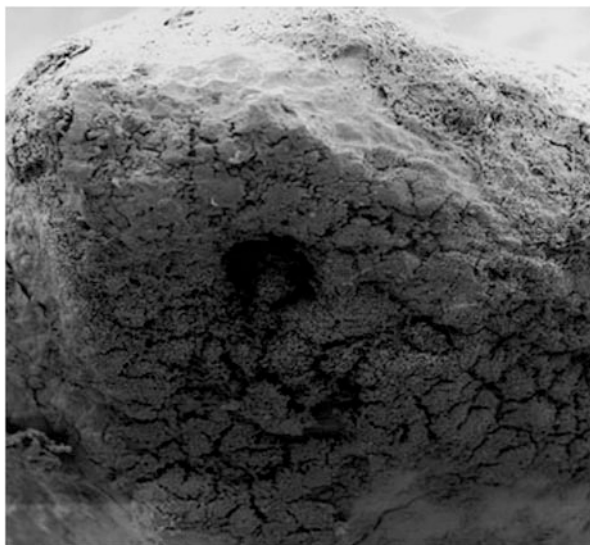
Extraradicular biofilm associated with the apical one third of roots of primary teeth with necrotic pulps and radiographically evident apical pathosis (Reproduced with permission of John Wiley & Sons, Inc from Rocha CT, Rossi MA, Leonardo MR, Rocha LB, Nelson-Filho P, Silva LA. Biofilm on the apical region of roots in primary teeth with vital and necrotic pulps with or without radiographically evident apical pathosis. *International Endodontic Journal* 41(8):664–9 ©2008)
